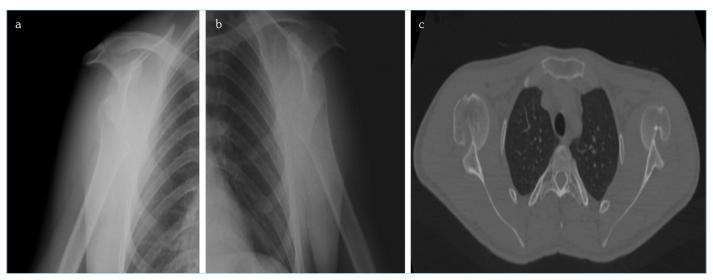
(a) Direct radiography of the right shoulder performed on admission (b) Direct radiography of the left shoulder performed on admission (c) CT scan performed at admission
